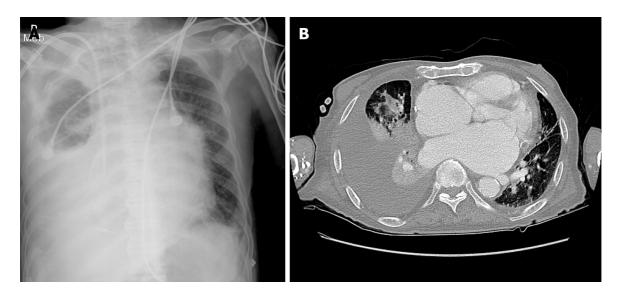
Radiographic imaging. A: Chest radiograph showing a large right pleural effusion and pulmonary edema; B: Chest computed tomography showing consolidation of the right middle lobe, total atelectasis of the right lower lobe, and a large right pleural effusion.
